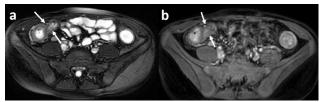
A 16-year-old girl with known ulcerative colitis. Axial balanced FFE (BTFFE) image (a) and axial contrast-enhanced T1-weighted with fat suppression image (b) show short segment wall thickening in the terminal ileum (white arrows). Coronal SSTSE T2-weighted image (c) shows wall thickening in ascending and descending colon (black arrows).
